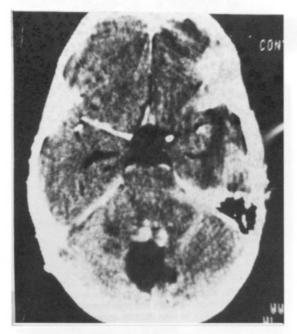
Postoperative CT scan showing the tumour cavity and a small residual part of the tumour.
